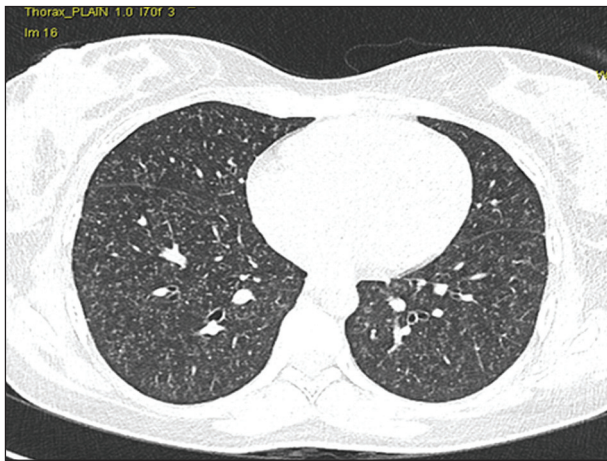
High resolution computed tomography of lung shows miliary pattern in bilateral lung fields with few coalescent larger nodules
